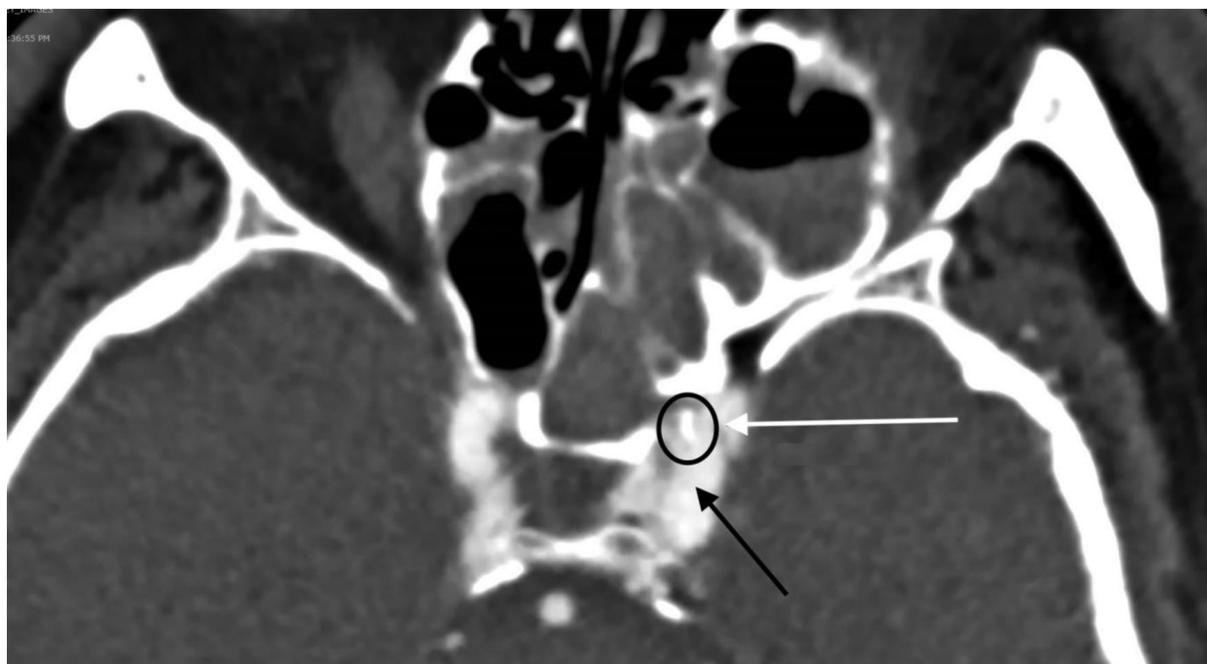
Computed tomography angiography, axial view, soft tissue window. Direct carotid-cavernous fistula (white arrow) is visualized due to arterial opacification of the cavernous sinus from the internal carotid artery (black arrow). Small fracture fragment of sphenoid bone (black circle) is noted near the internal carotid artery and immediately adjacent to the fistula.
